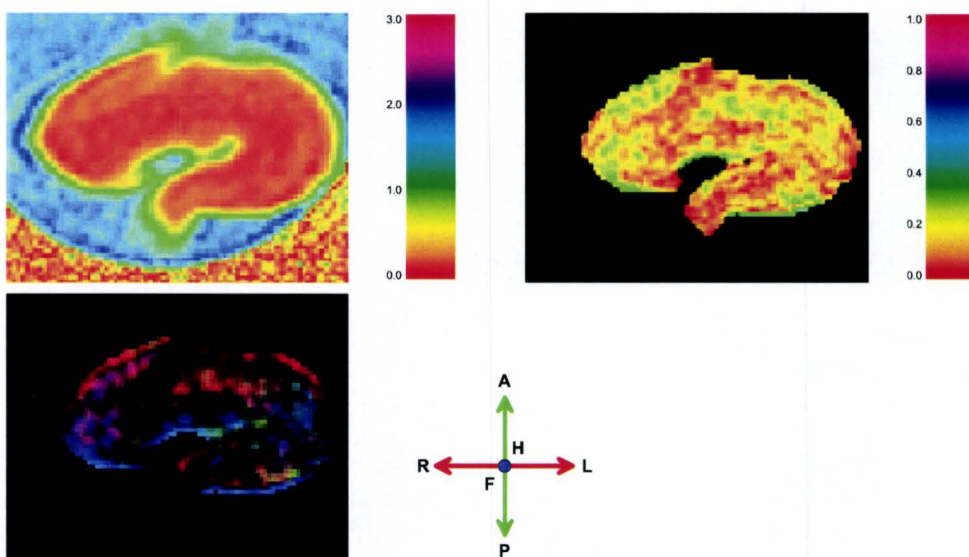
MR images of a fixated complete hippocampus, showing Apparent Diffusion Coefficient (top left), Fractional Anisotropy (top right) and Color Code (bottom left) of a transverse slice. The *ADC* is given in units of $10^{-9} \text{ m}^2/\text{s}$. Color Code image shows the directional preference of diffusion. Note that Color Code image differs from Figure 5.21. This is partly due to a different sample orientation.
